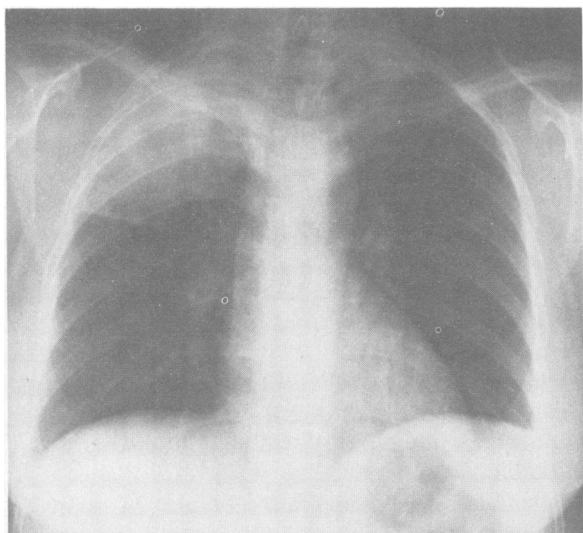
Initial chest roentgenogram, showing consolidation of the right upper lobe.
